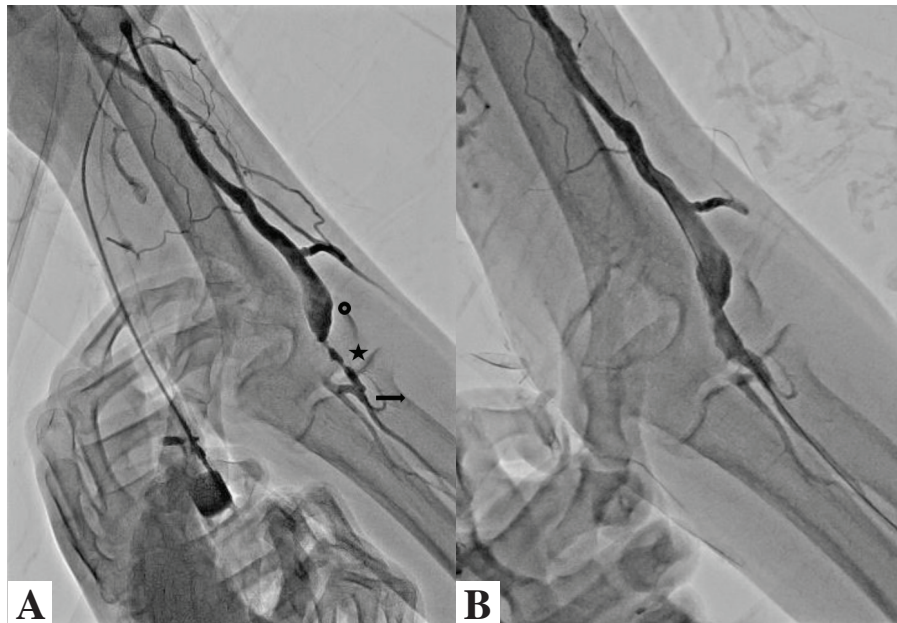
Narrowing in the great saphenous vein graft (A) before and (B) after balloon dilatation. Circle: Cephalic vein, star: Saphenous vein graft, arrow: radial artery. Since the image reflects reflux angiography, the brachial artery and the cephalic vein were compressed with the hand. This is the reason why the operator's hand can be seen in the X-ray beam.
